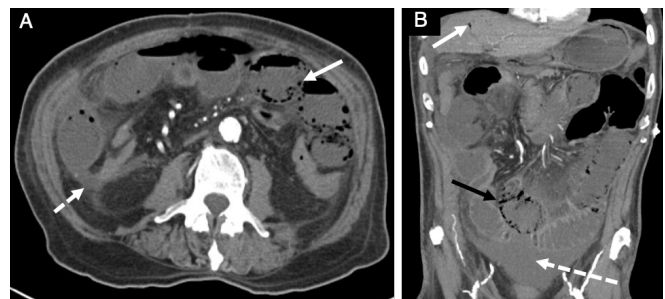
Small bowel obstruction with evidence of bowel ischemia (A) Axial CT shows small bowel pneumatosis (*solid arrow*) and mesenteric edema (*dashed arrow*). (B) Coronal CT shows portal venous gas (*solid white arrow*), small bowel pneumatosis (*solid black arrow*), and intra-abdominal free fluid (*dashed arrow*). The patient underwent exploratory laparotomy which revealed a closed-loop obstruction due to an adhesive band. The patient required small bowel resection at both the index operation and second-look laparotomy. The patient was left with approximately 70 cm of small bowel and went on to develop short bowel syndrome.
